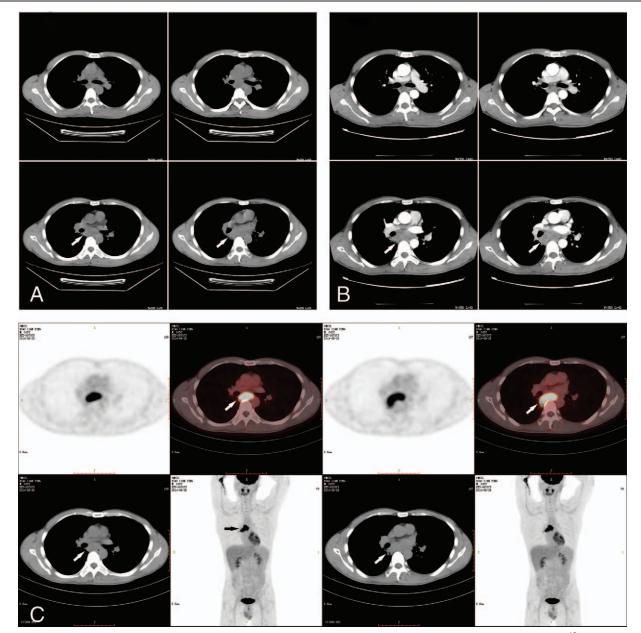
(A, B) Chest CT scan and contrast-enhanced scan showing subcarinal mediastinal masses. (C) PET-CT images showing intense ¹⁸fluorodeoxyglucose accumulation in mediastinal masses. White arrows indicate the nidus. CT=computed tomography, PET-CT = positron-emission tomography.
